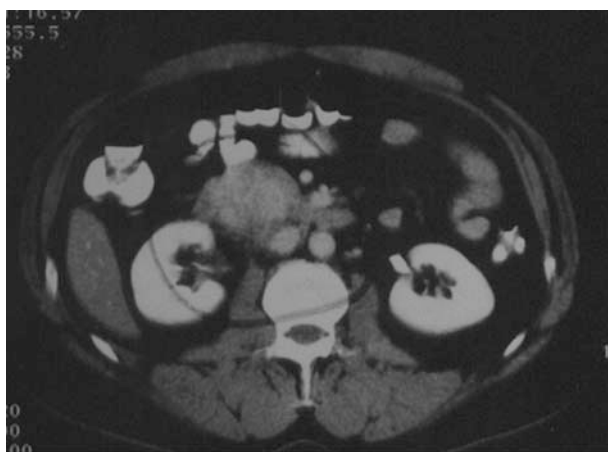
Computed tomography scan from October 8, 2002, shows a hyperdense mass at the junction of the second and third portions of the duodenum and the uncinate process of the pancreas (circled).
